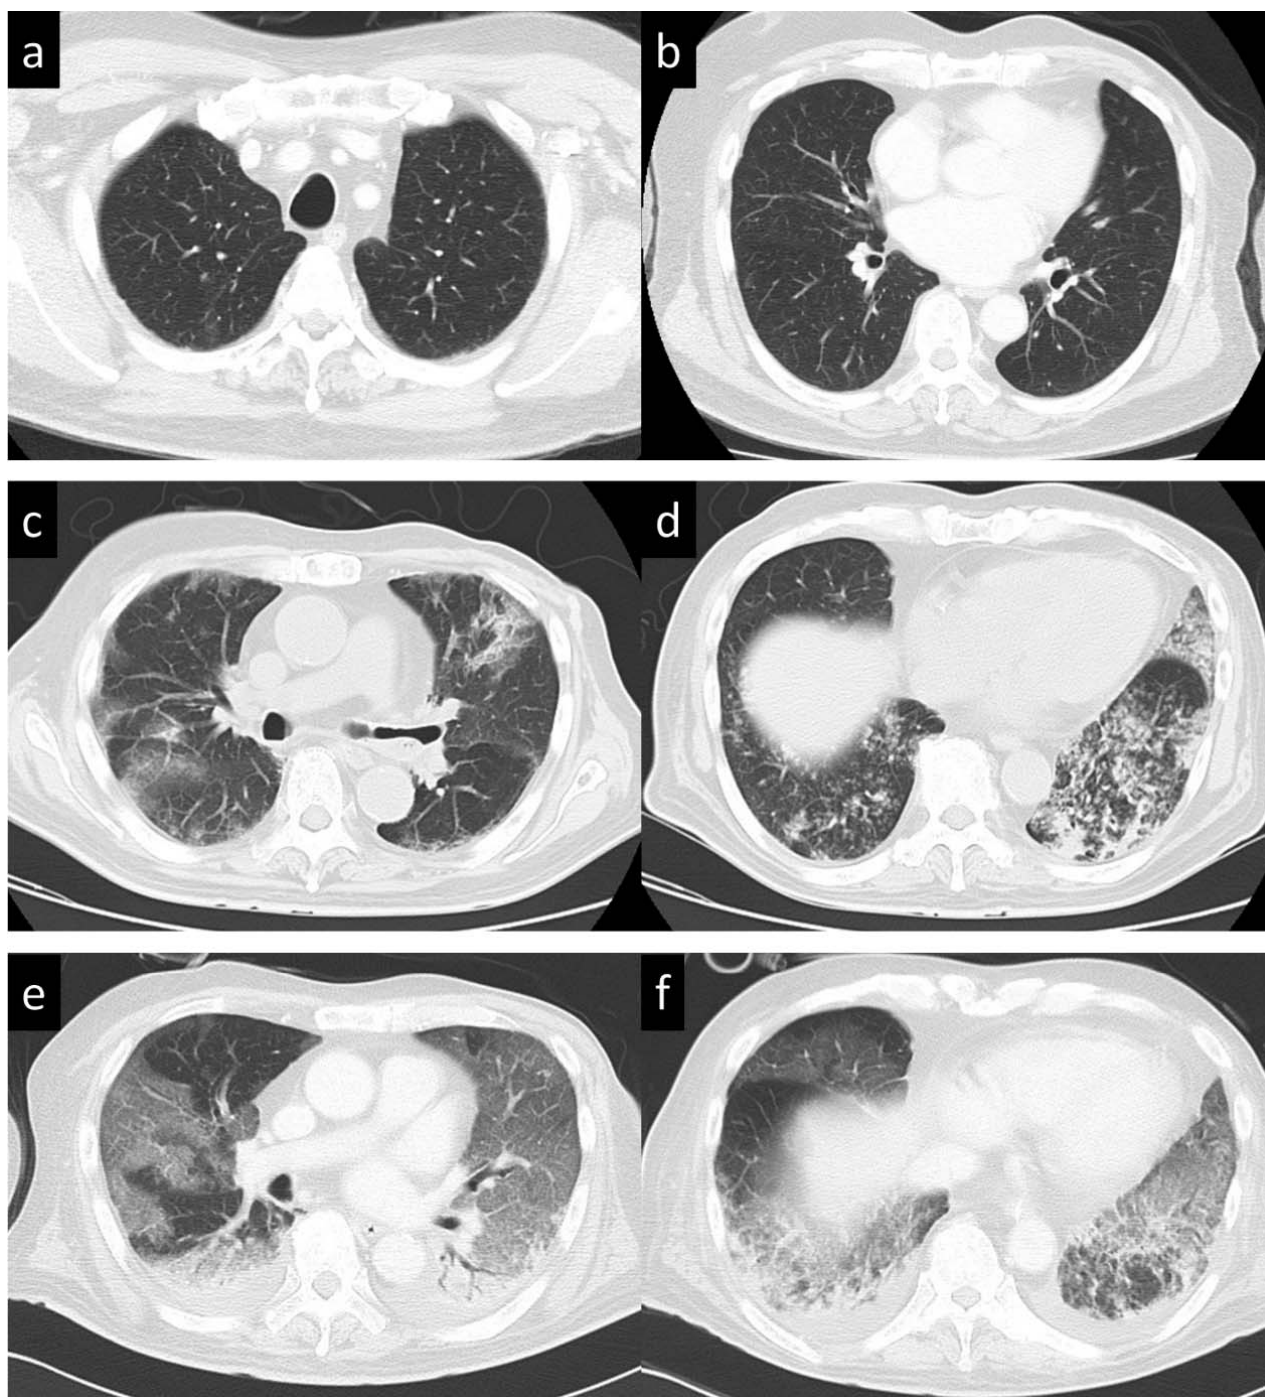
Pulmonary CT representing ILD before cetuximab exposure (a, b), ground glass opacities in both upper and middle lung fields (c), consolidation in the lower left lung field (d) at the onset of ILD, extensive ground glass opacities in both lung fields, and traction bronchiectasis at 7 days after onset of ILD (e, f).
